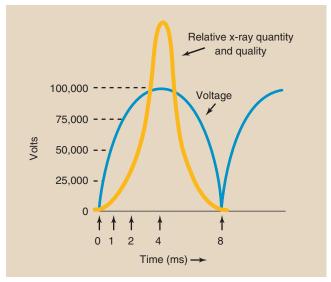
As the voltage across the x-ray tube increases from zero to its peak value, x-ray intensity and energy increase slowly at first and then rapidly as peak voltage is obtained.
